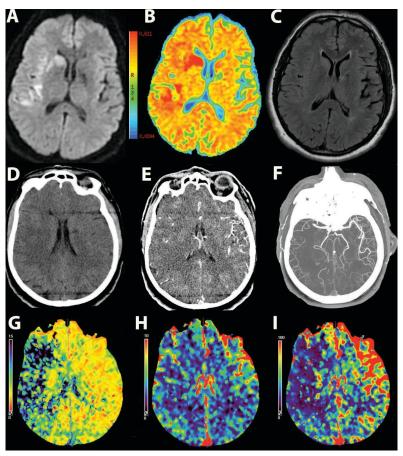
Case #1. Neuroimaging in 24 h. A-C. Magnetic-resonance imaging (MRI): A. Diffusion weighted imaging (DWI). B. The apparent diffusion coefficient (ADC) map. C. Fluid-attenuated inversion recovery (FLAIR). D-I. Computed tomography (CT) scans: D. Non-contrast CT. E. CT-angiography source images (CTASI). F. Maximal intensity projection (CT-angiography). G-I. CT-perfusion study: G. The mean transit time (MTT) map. H. The cerebral blood volume (CBV) map. I. The cerebral blood flow (CBF) map.
